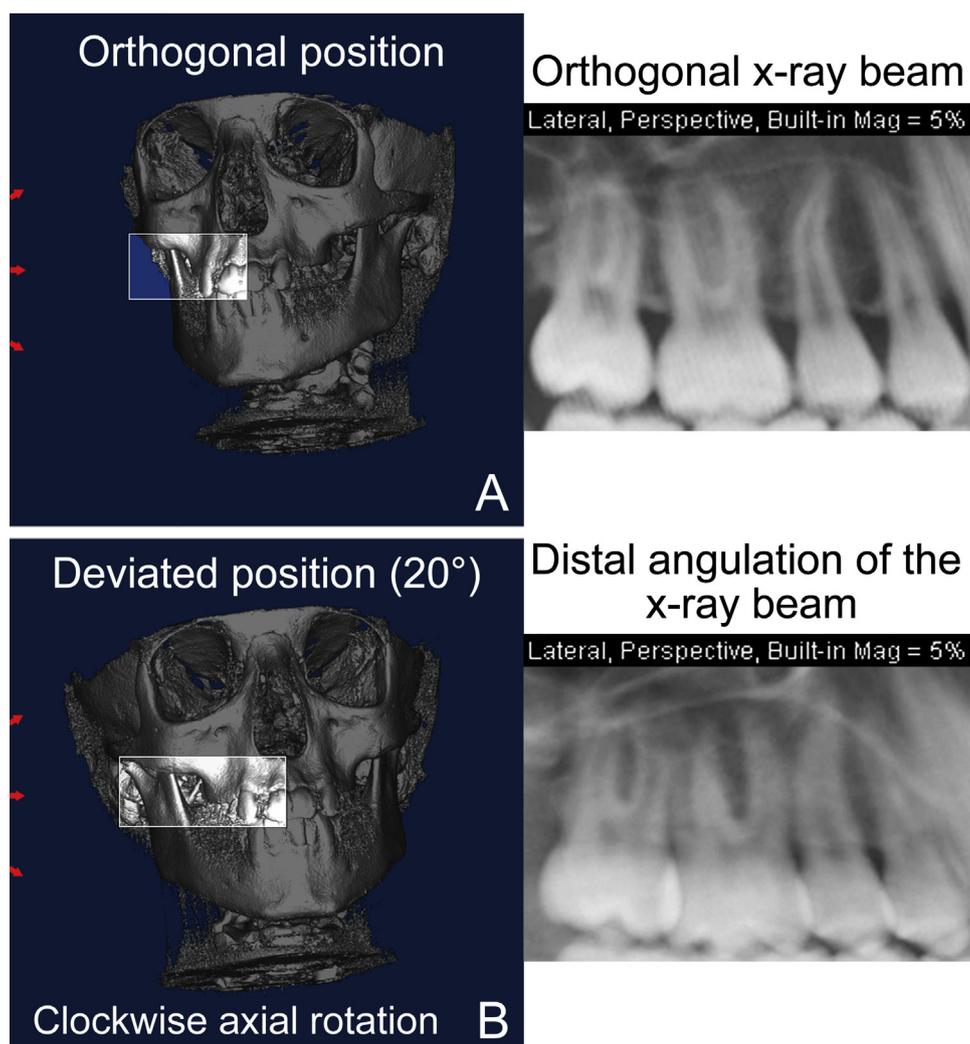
Obtainment of CBCT synthesized periapical radiographs. A, Synthesized periapical radiograph taken with orthogonal x-ray. B, Synthesized periapical radiograph taken with distal angulation of the x-ray beam (20°).
